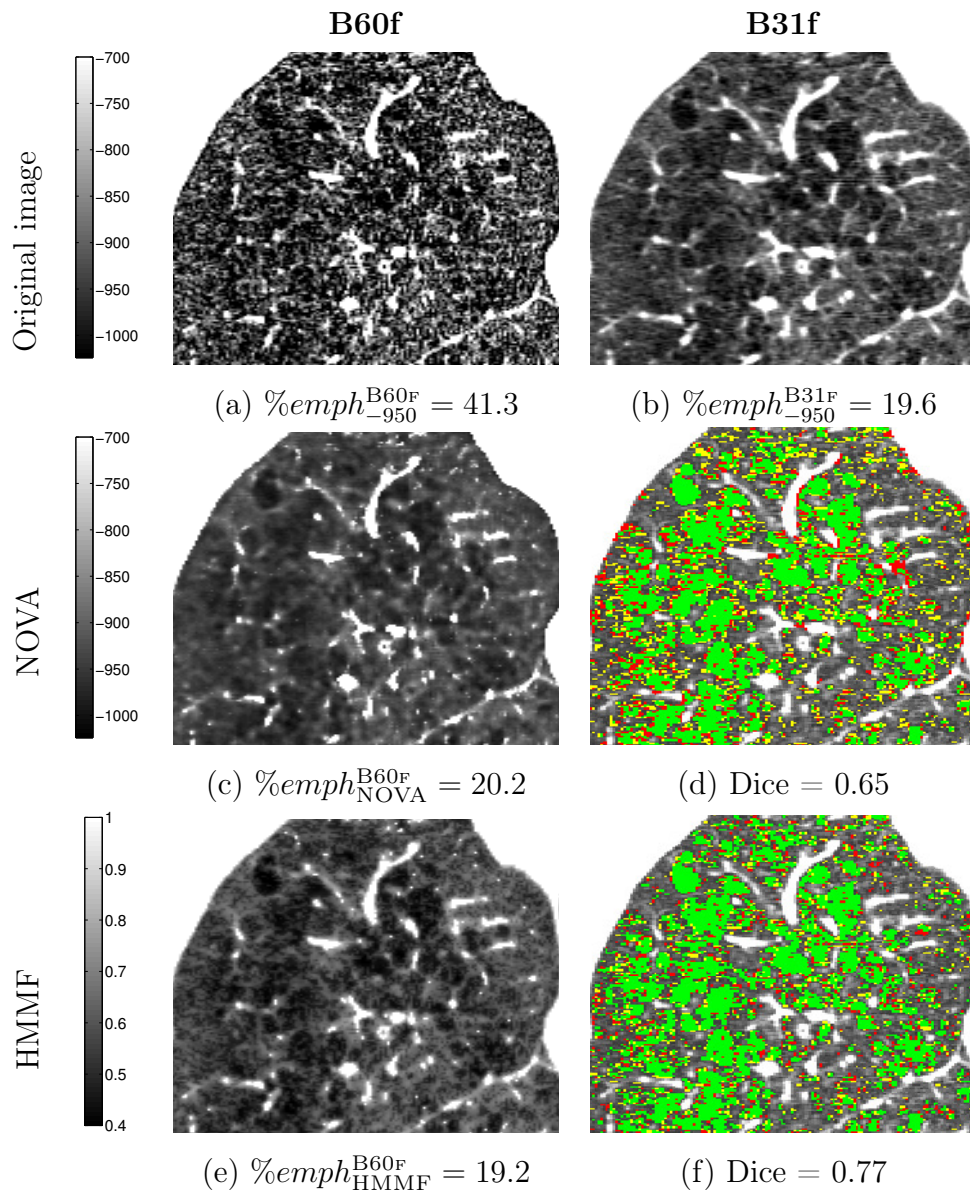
Cropped views of a pair of coronal slices from B60f (a) and B31f (b) reconstructions of a single CT acquisition, the output of NOVA filtering (c), the HMMF MAP estimate q_2^* (e), and the corresponding emphysema mask overlaps (d),(f) using $\%emph_{-950}^{B31F}$ as reference. The masks use the following color code: green: true positive, yellow: false negative, red: false positive. For visualization, the MAP estimate in (e) is windowed to resemble the intensity range of (b).*
